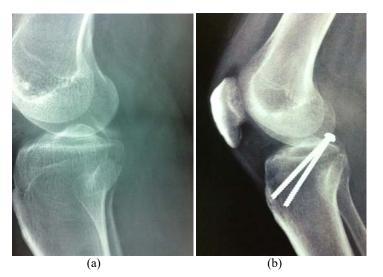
Preoperative (a) and postoperative (b) Xrays.
